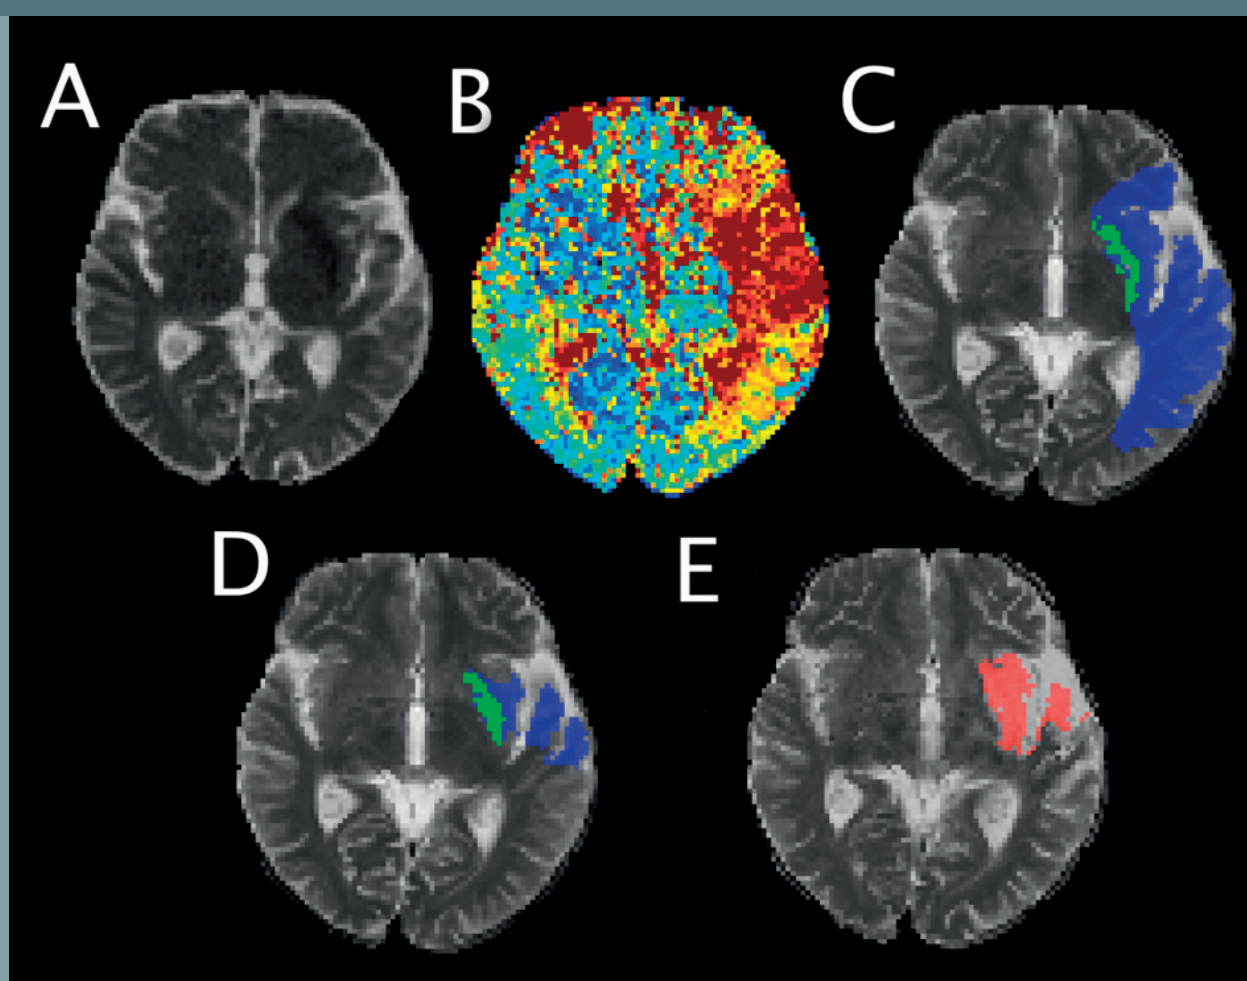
Imaging of an acute stroke case, showing ADC from DWI imaging (A), Tmax from perfusion imaging (B), and the threshold-based ischemic core (green) and penumbra (blue) (C). The output of FASTER (D) shows a similar infarct core (green) but a smaller region at risk (blue). The 90-day T2 follow-up (E) shows that tissue damage was restricted to the region predicted by FASTER, despite perfusion restoration to the territory at risk (TICI 1).
